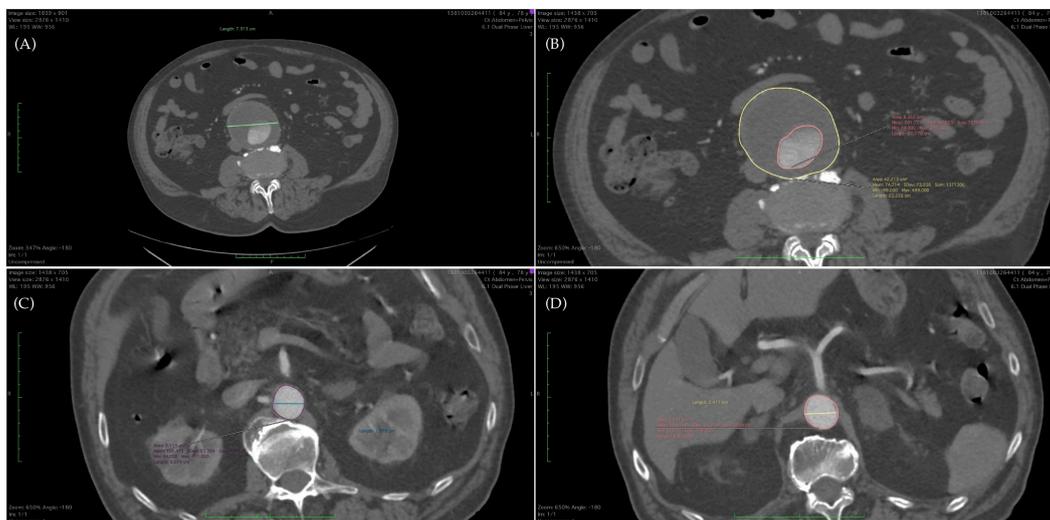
CT angiography: (A) maximal diameter of AAA (axial section); (B) surface of AAA at maximal diameter (yellow) and surface of lumen (orange); (C) diameter and surface of aorta at renal level; and (D) diameter and surface of aorta at celiac trunk level.
